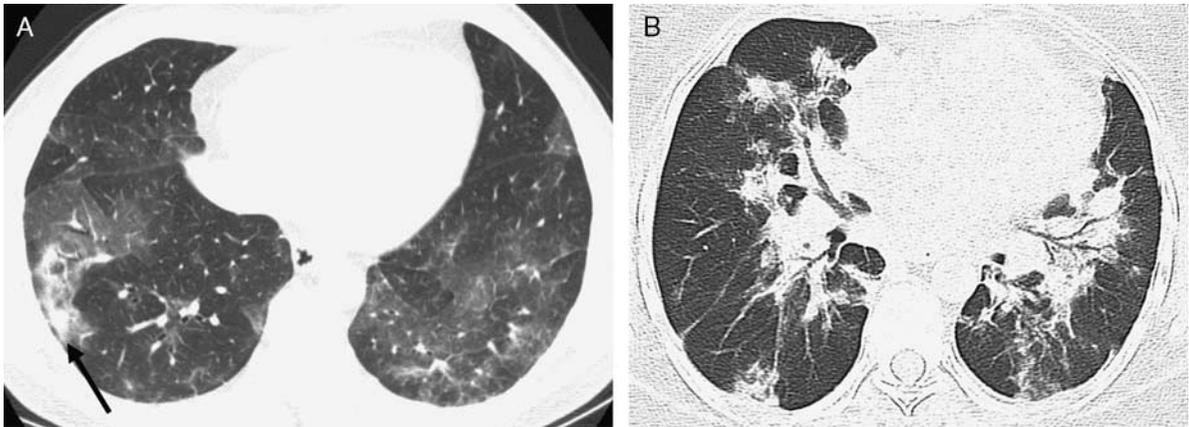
A and B, Organizing pneumonia pattern. Axial HRCT (A) demonstrates patchy bilateral GGO and small regions of consolidation (arrow). Pathologically the ground glass corresponded to interstitial inflammation and the consolidation to areas of organizing pneumonia. Rarely HP may closely mimic cryptogenic organizing pneumonia (B) in which case the consolidation is the predominant feature.
